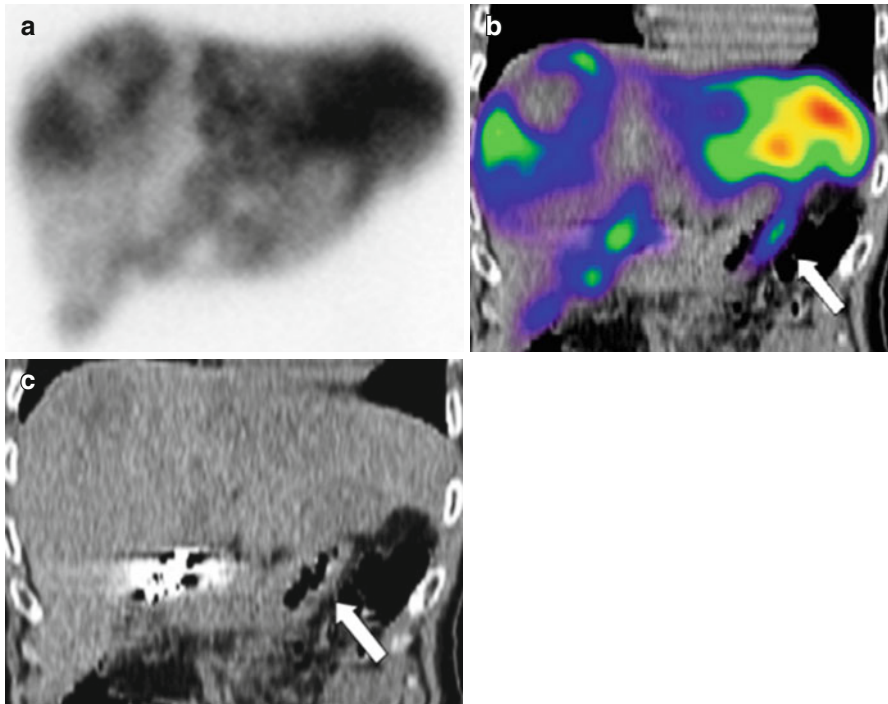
Duodenal accumulation (*arrows*) in a patient with colorectal cancer, not definable on planar images: planar scan (a), SPECT/CT coronal view (b) and CT coronal view (c) (Reprinted from Ahmadzadehfar et al. [32] with permission of the Society of Nuclear Medicine)
